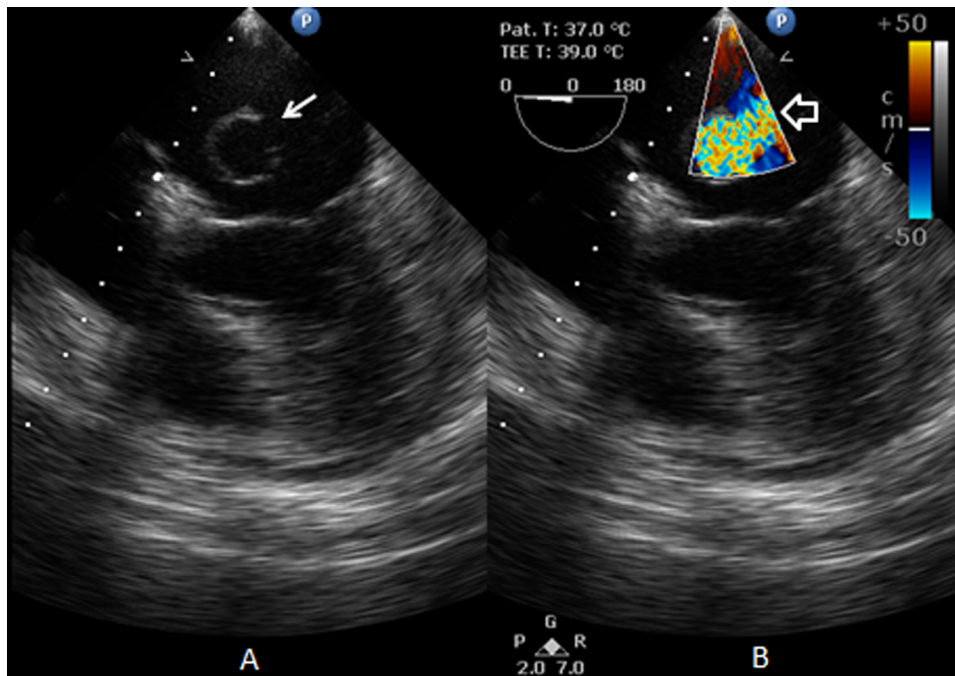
Transesophageal 4 chamber, 2D-Echo (A) and color image (B) showing the submitral aneurysm in cross-section in left atrium (solid arrow) with systolic regurgitation jet through the ruptured site (hollow arrow).
